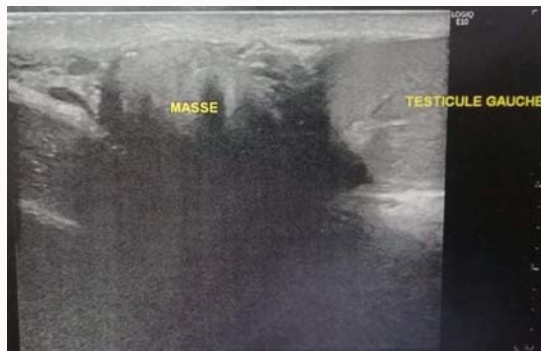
Scrotal ultrasound showing the epididymal mass.
